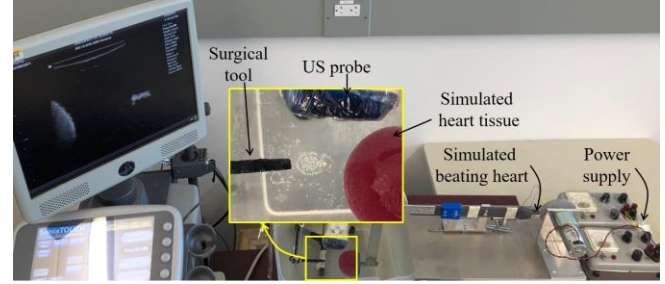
The experimental setup for ultrasound image acquisition.
